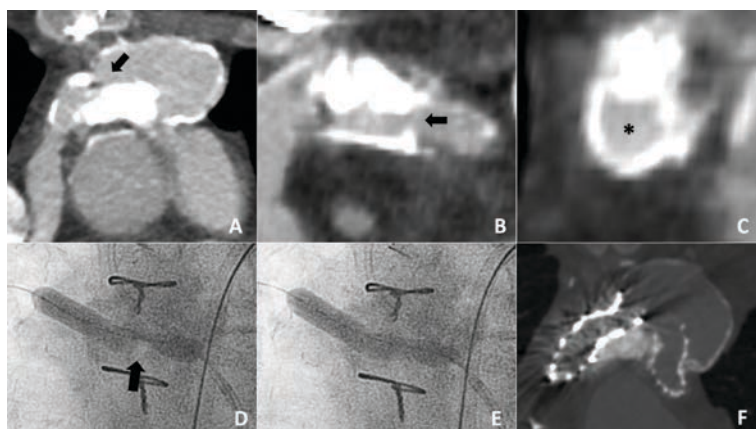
Pre-, intra-, and post-procedural imaging in Patient 1. Pre-procedural multiplanar reformatted computed tomography angiography (CTA) images in the (A) axial, (B) sagittal, and (C) coronal projections demonstrate heavy calcifications of the ostial right pulmonary artery (black arrows) in a patient with D-transposition of the great arteries post-LeCompte maneuver. (D) At the initiation of intravascular lithotripsy (IVL), a discrete mid-balloon waist was present (black arrow), which (E) fully resolved with the following IVL. (F) A post-procedural CTA reveals patent branch pulmonary artery stents.
